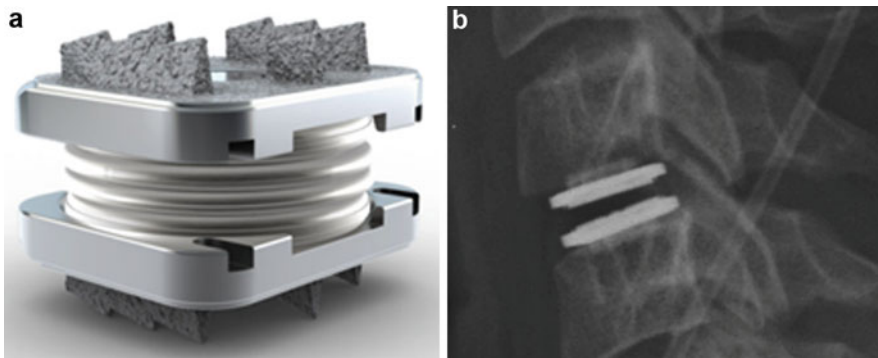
M6-C artificial disc: (a) device; (b) lateral X-ray after implantation
